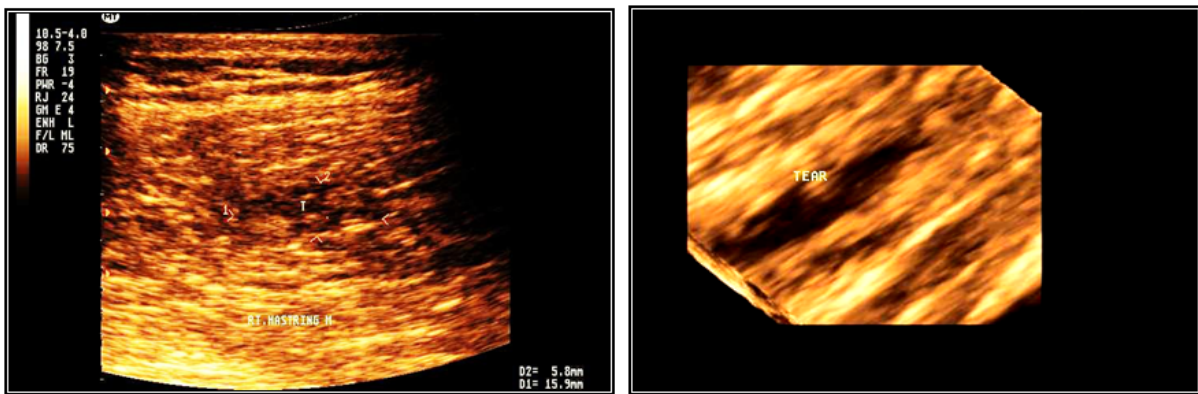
a. 2D sonography showing small hypoechoic muscle tear (arrow), b. 3D sonography with surface rendering for the right Hamstring muscle tear (clinically grade 11 muscle strain)
